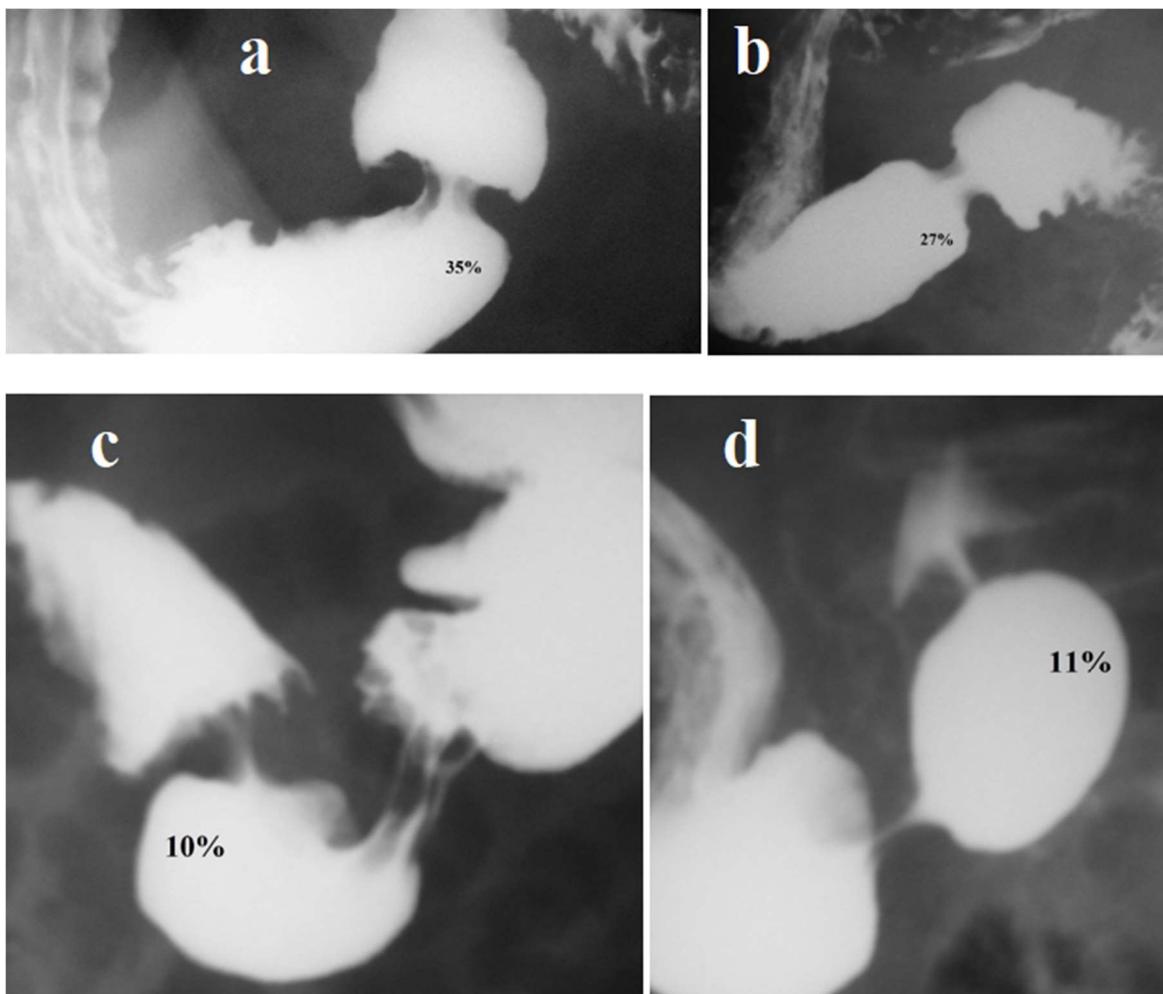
Radiographs of the gastroduodenal zone in the elderly with symptoms of dyskinesia of the digestive tract. The figures show what percentage is the width of the pyloric sphincter (PS) of the width of the base of the duodenal bulb during antral systole. (a-b). PS is wide (27-35%) and short. In these cases, the body of the stomach is almost empty of contents, which indicates a rapid evacuation from the stomach. (c-d). PS is narrow (10-11%) and long, and the stomach contains a
